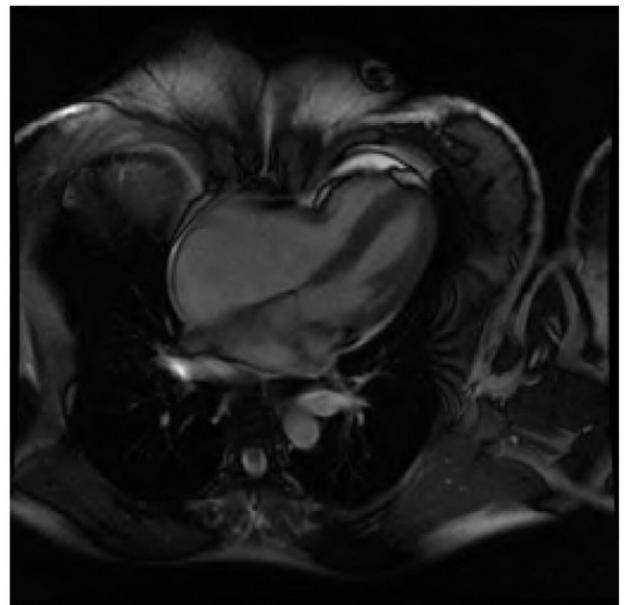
Magnetic resonance imaging demonstrating compression of the right ventricle.
